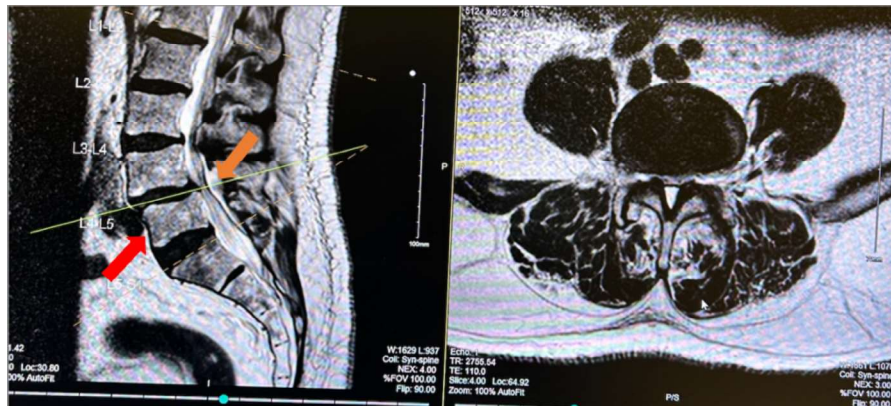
Sagittal and Axial MRI of Spine Before Back Surgery in 2010. MRI shows degeneration of discs (red arrow) and stenosis of neural foraminal narrowing from L1-S1 (orange arrow).
